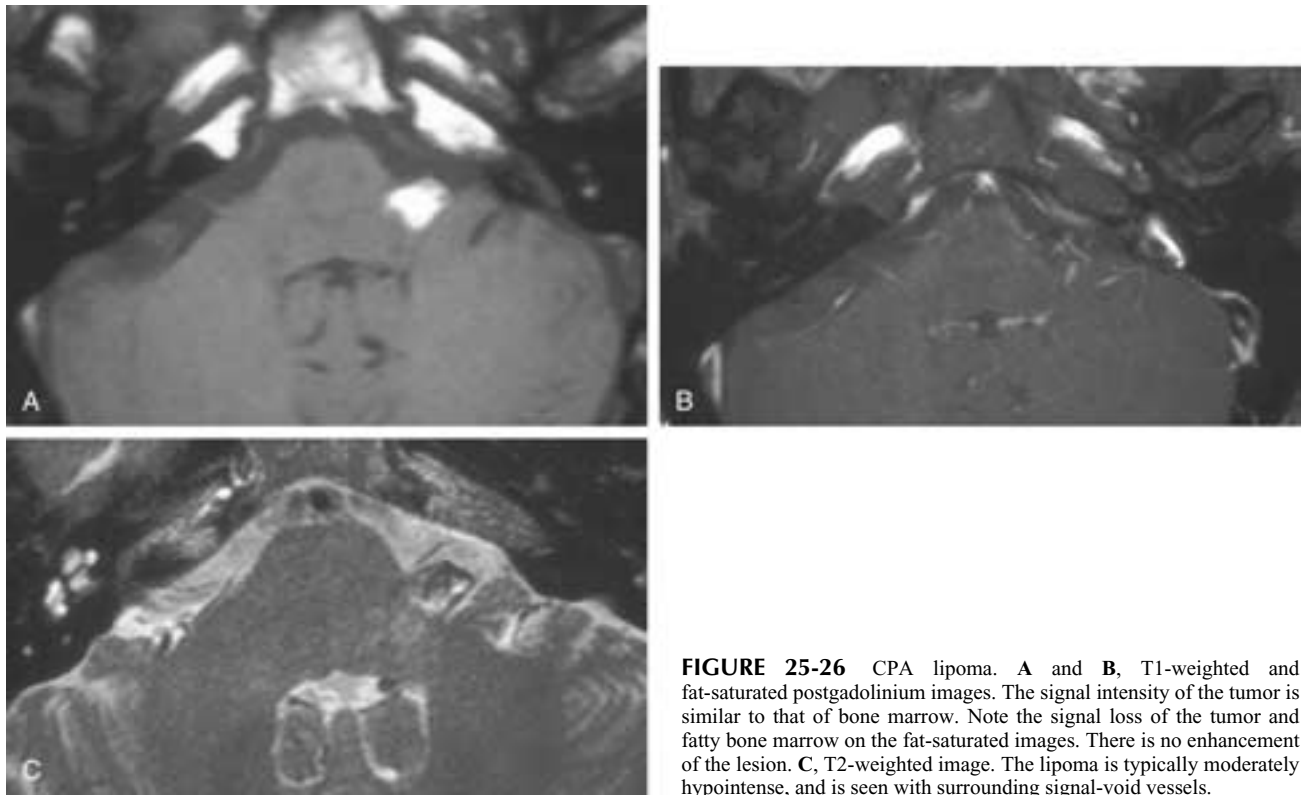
CPA lipoma. A and B, T1-weighted and fat-saturated postgadolinium images. The signal intensity of the tumor is similar to that of bone marrow. Note the signal loss of the tumor and fatty bone marrow on the fat-saturated images. There is no enhancement of the lesion. C, T2-weighted image. The lipoma is typically moderately hypointense, and is seen with surrounding signal-void vessels.
